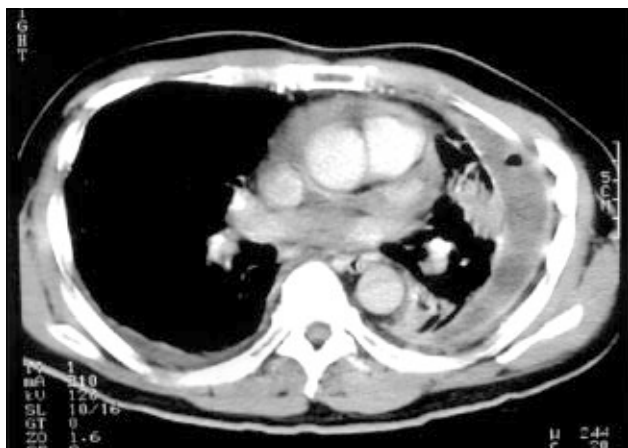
Computed tomography of the thorax showing thickened left parietal pleura associated with left lung collapse
